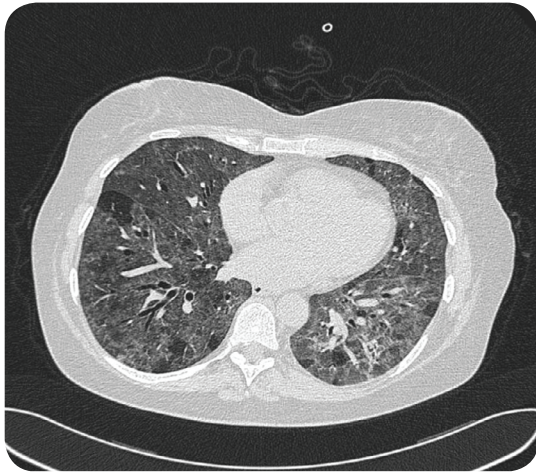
A high resolution CT scan in the axial plane of an individual with hypersensitivity pneumonitis. There are multiple centrilobular ground glass nodules and anterior subpleural reticulation.
